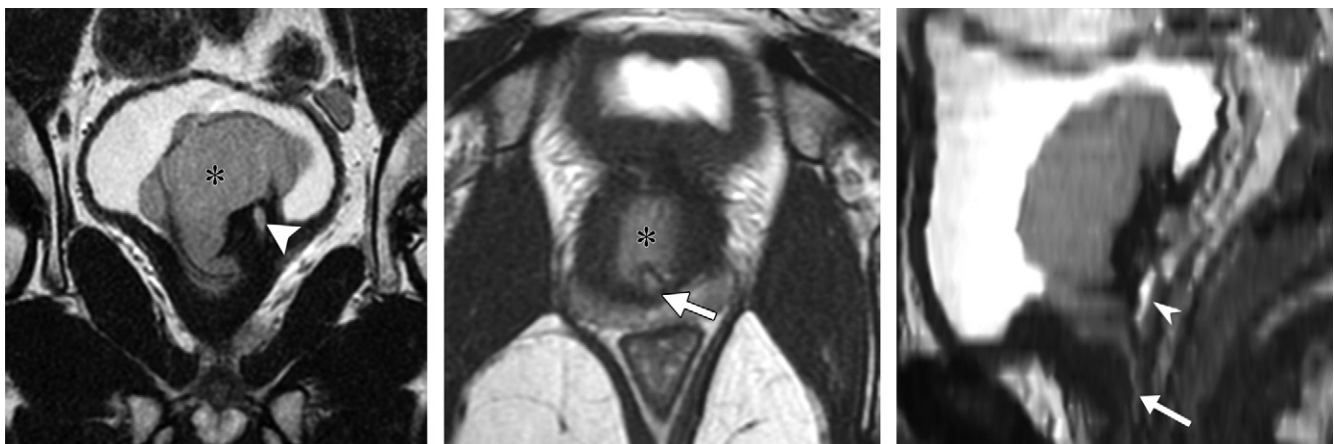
(a) Coronal T2-weighted (repetition time msec/echo time msec, 4574/86.5) MRI of the pelvis shows the left ureter (arrowhead). (b) Axial T2-weighted (3000/85.4) MRI of the pelvis shows the urethra (arrow). Note the cecoureterocele (*), which is anterior to and does not communicate with the urethra. (c) Sagittal reformatted MRI from b shows the right ejaculatory duct (arrowhead) and urethra (arrow).
